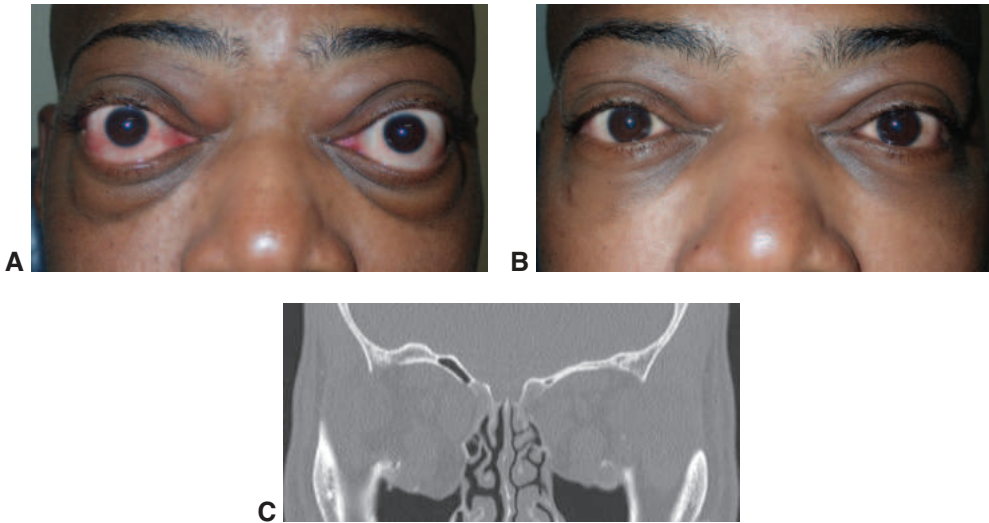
Orbital decompression for thyroid eye disease. Before (A) and after (B) bilateral, 3-wall orbital decompression surgery. C, Postoperative coronal computed tomography (CT) imaging showing maximal bone removal from the medial wall, floor, and lateral wall of each orbit. (Courtesy of Steven M. Couch, MD, and Robi Maamari, MD.)
